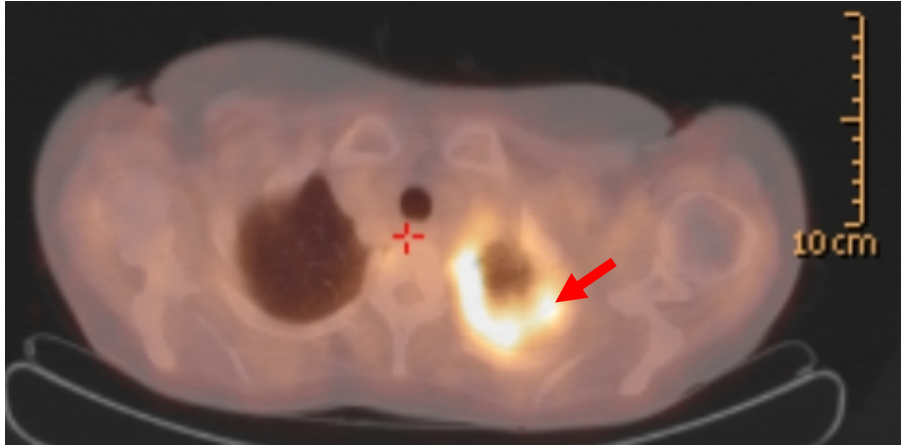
Patient's positron emission tomography - computed tomography demonstrating a hypermetabolic lesion (SUVmax: 5.9) with pleural invasion in the apicoposterior segment of the left lung.
